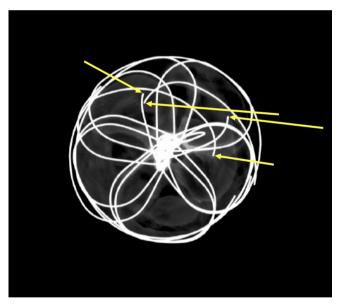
Postremoval radiograph of the Cardioform Septal Occluder from Case 2. This radiograph demonstrates four separated wire frame fractures (yellow arrows). There is a total of eight open wire ends [Color figure can be viewed at wileyonlinelibrary.com]
